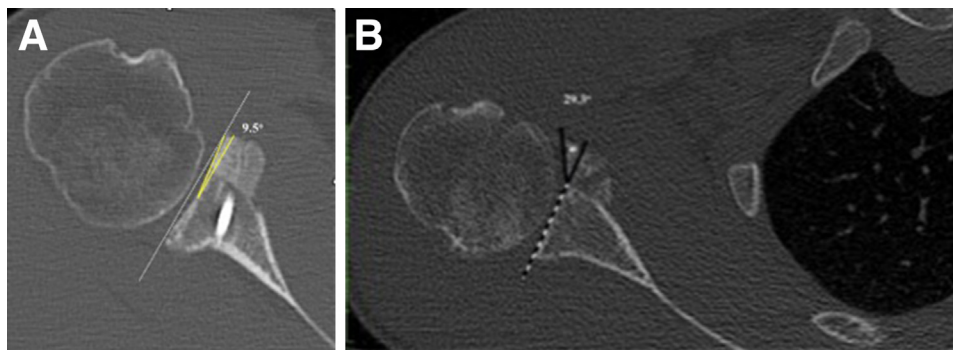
(A) Axial cut of a computed tomography (CT) scan taken at 8 months after right shoulder stabilization with the distal tibia allograft showing that an allograft angle value closely resembles the native glenoid anatomy. (B) Axial cut of a CT scan taken at 8 months after right shoulder stabilization with the distal tibia allograft showing an allograft angle of 29.3° to the native glenoid. This distal tibia allograft healed the worst of the series, but still showed incorporation at the surface and on multiple CT axial cuts.
